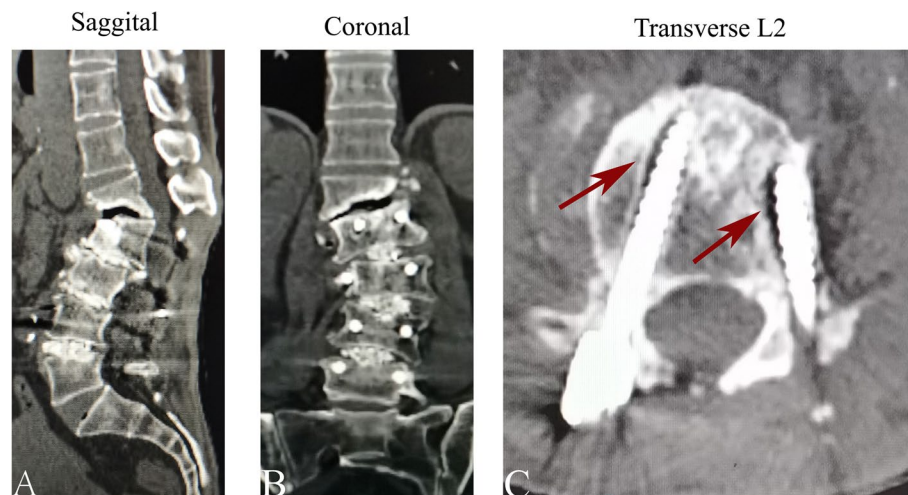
At the 24-month postoperative follow-up, the sagittal and coronal CT scans (A, B) confirmed L2-3, L3-4, and L4-5 bony fusion; the sagittal image (A) showed severe degeneration of the L1-2 segment, intervertebral space and vertebral collapse, and the formation of proximal junctional kyphosis; the coronal image (B) suggested proximal degeneration and collapse; the L2 transverse scan (C, red arrow) revealed radiolucent zones around the bilateral screw tips
